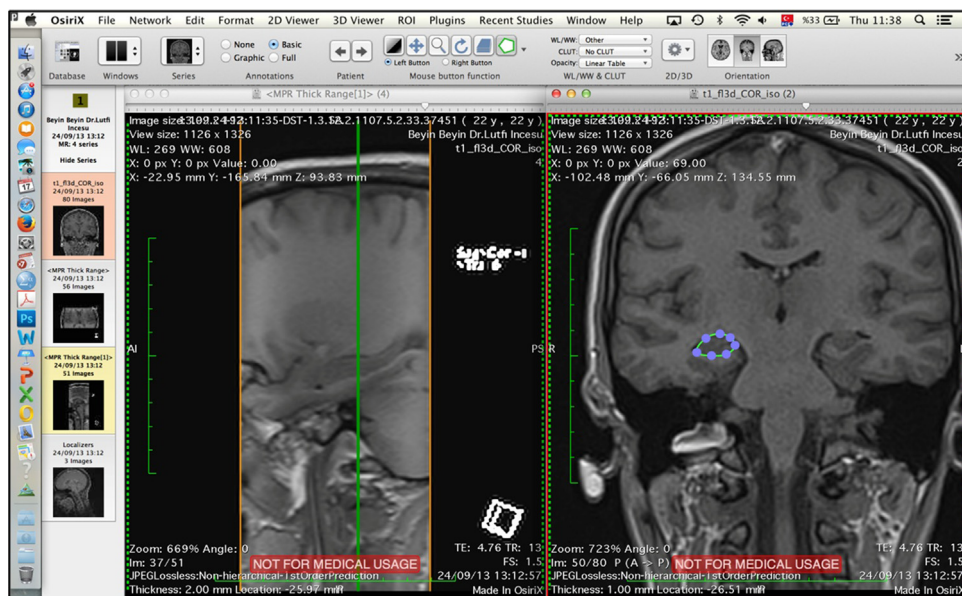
MR images from one subject showing the hippocampus. Images were analysed on the software OsiriX 3.2.1 workstation. Hippocampal volumes were estimated using the output data from this process.
